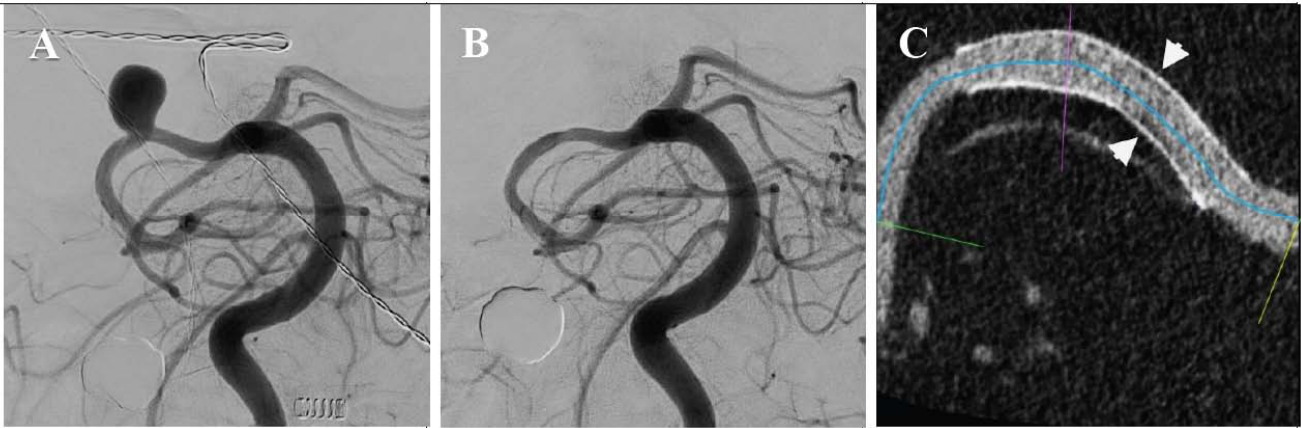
85-year-old patient with a large right posterior cerebral artery (PCA) P2 segment aneurysm treated with a Silk Vista Baby FD (2.75 mm × 10 mm), demonstrating complete occlusion at 6-month follow-up. A: DSA in the working projection (WP), showing the unruptured P2 aneurysm. B: Six-month follow-up DSA in the same WP confirming complete aneurysm occlusion. C: Six-month follow-up Vaso-CT with maximum intensity projection (MIP) reconstruction, revealing mild neointimal hyperplasia (arrows) within the FD without significant stenosis.
